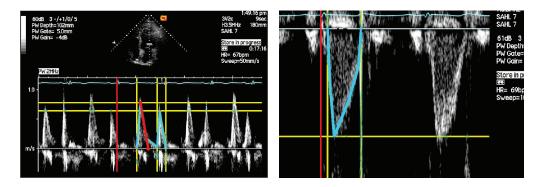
Mitral and LV outflow tract pulsed wave Doppler are outlined in the designed computer program Echotools for measurement. The vertical lines indicate some of the time intervals that are calculated.
